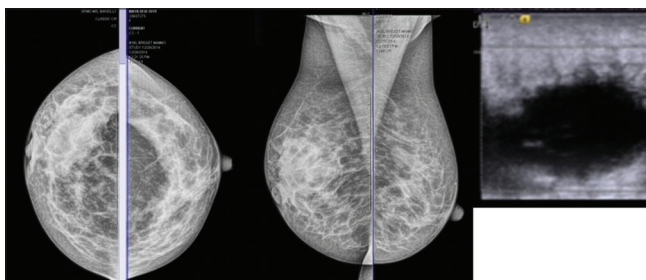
Mammography showed asymmetric dense parenchyma, sonography showed definite mass with infiltration. Fine-needle aspiration cytology malignant
